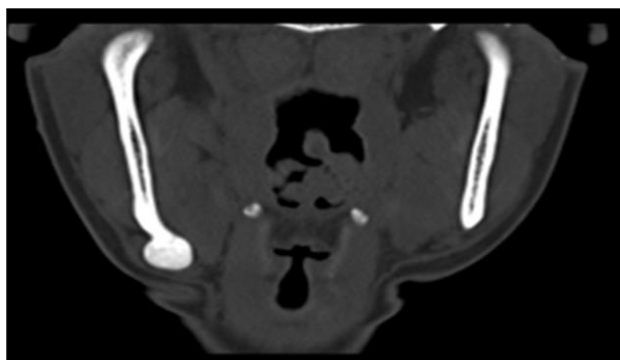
CT scan view revealed a well-defined radio-dense area present on the right lateral side of the lower border of mandible.
